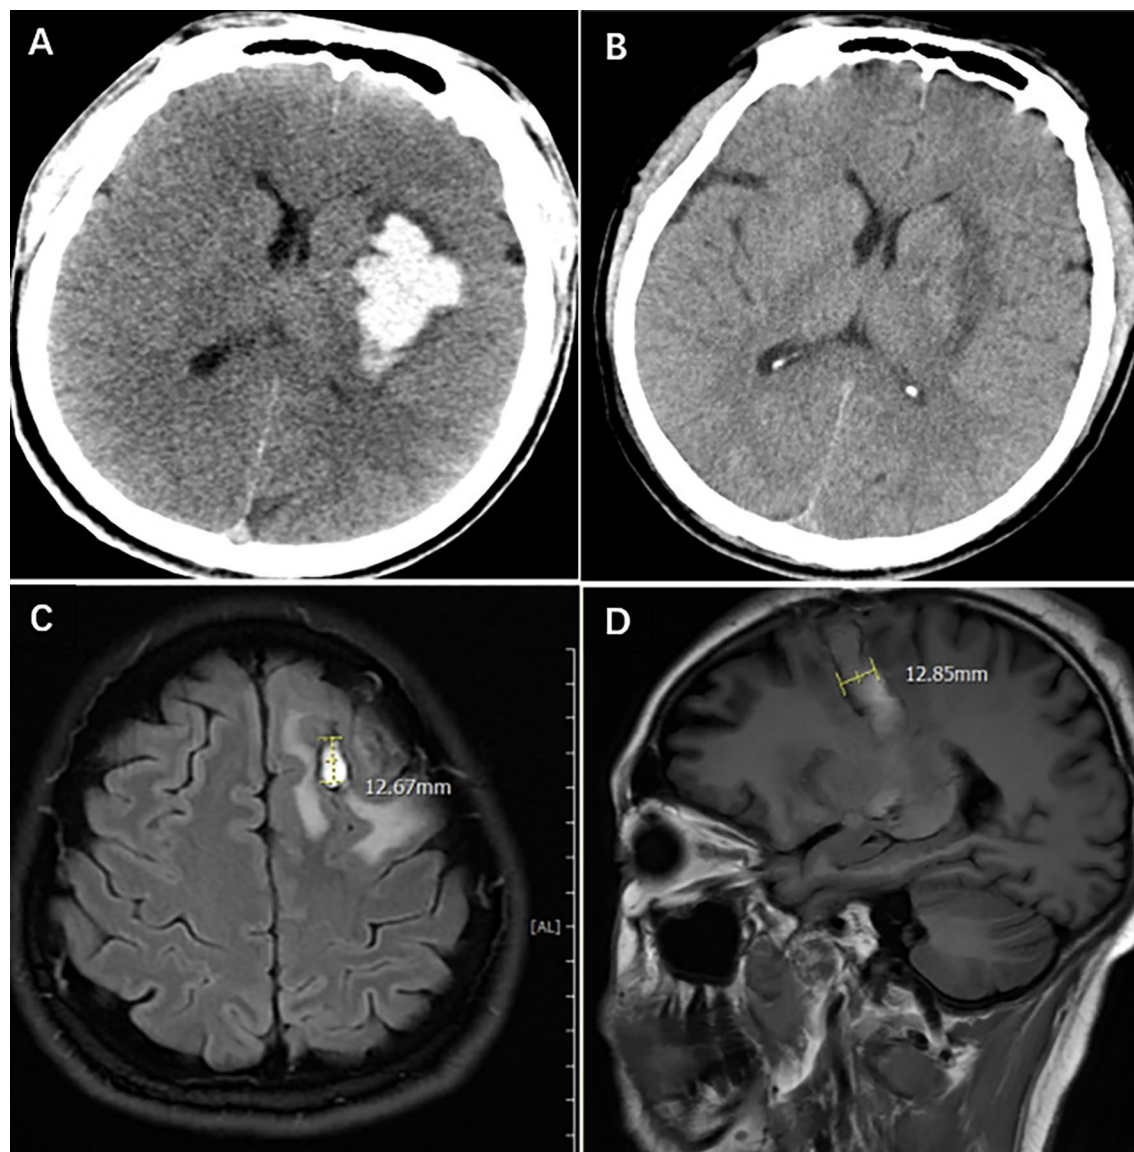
Brain injury after hematoma clearance. A Preoperative CT. B Postoperative review CT. C Diameter of the cortical incision is about 13 mm. D Diameter of the cerebral sheath channel is about 13 mm
